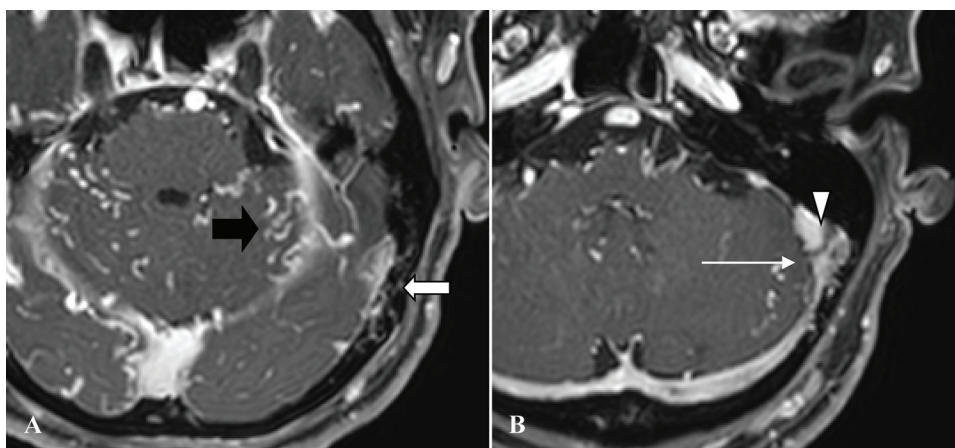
Dural AVF at the left sigmoid sinus. (A, B) Axial 3D contrast-enhanced THRIVE MRI shows transosseous enhancing curvilinear structures adjacent to dural venous sinus wall (thick white arrow), consistent with transosseous feeding arteries. There are low intensity curvilinear structures within dural venous sinus (arrow head). Shaggy sinus at left sigmoid sinus (thin white arrow) and cortical venous dilatation (black arrow) is also observed.
